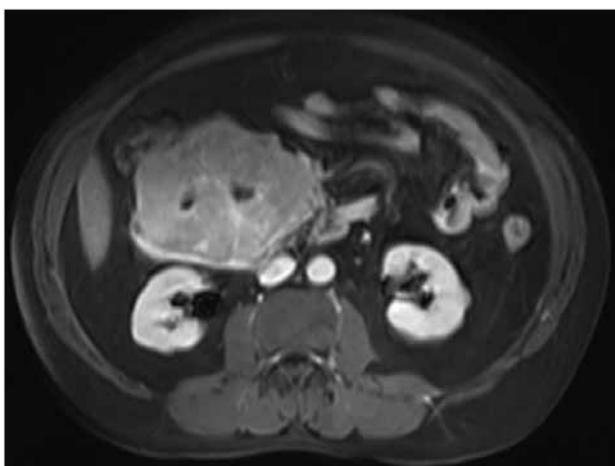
MRI demonstrating the pancreatic mass (axial view)
